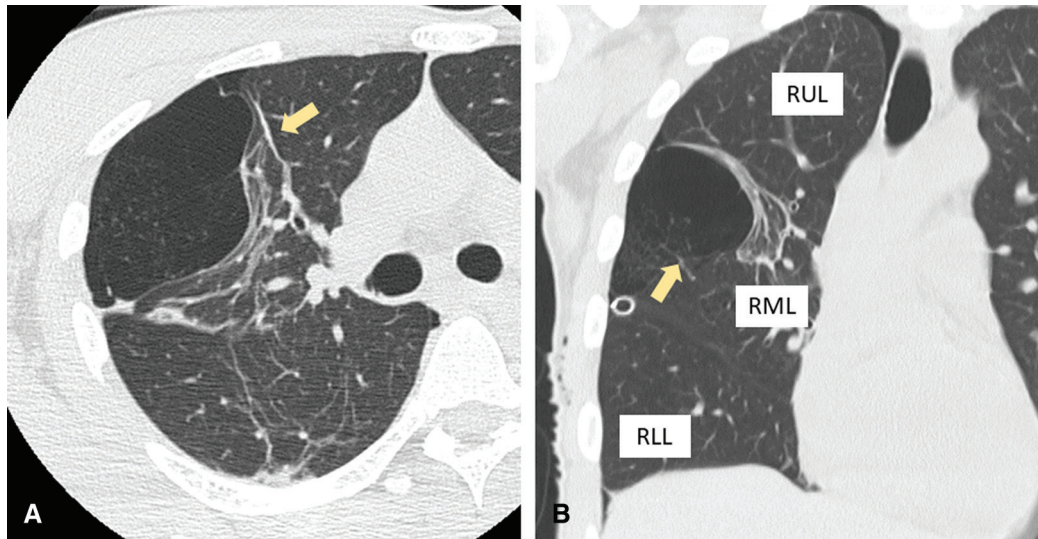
Axial (A) and coronal (B) chest CT views showing an emphysematous lesion with a maximum diameter of 8 cm in the right middle lobe occupying less than 30% of the right hemithorax (arrows). CT: computed tomography; RLL: right lower lobe; RML: right middle lobe; RUL: right upper lobe
